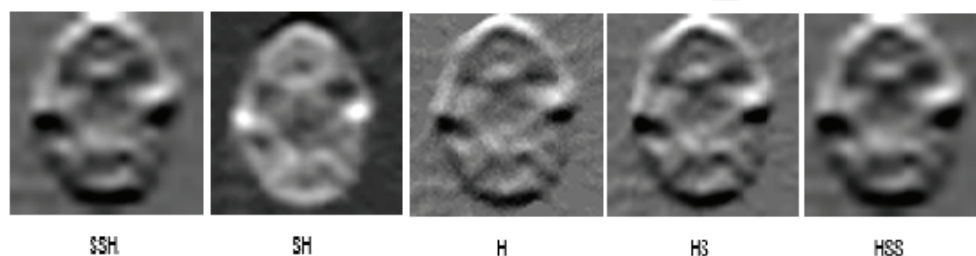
Effects of image details smoothing by the  $S$  operation used after ( $SH$ ,  $SSH$ ) and before ( $HS$ ,  $HSS$ ) the basic operation  $H$  performed on a *SPECT* image of a brain.
